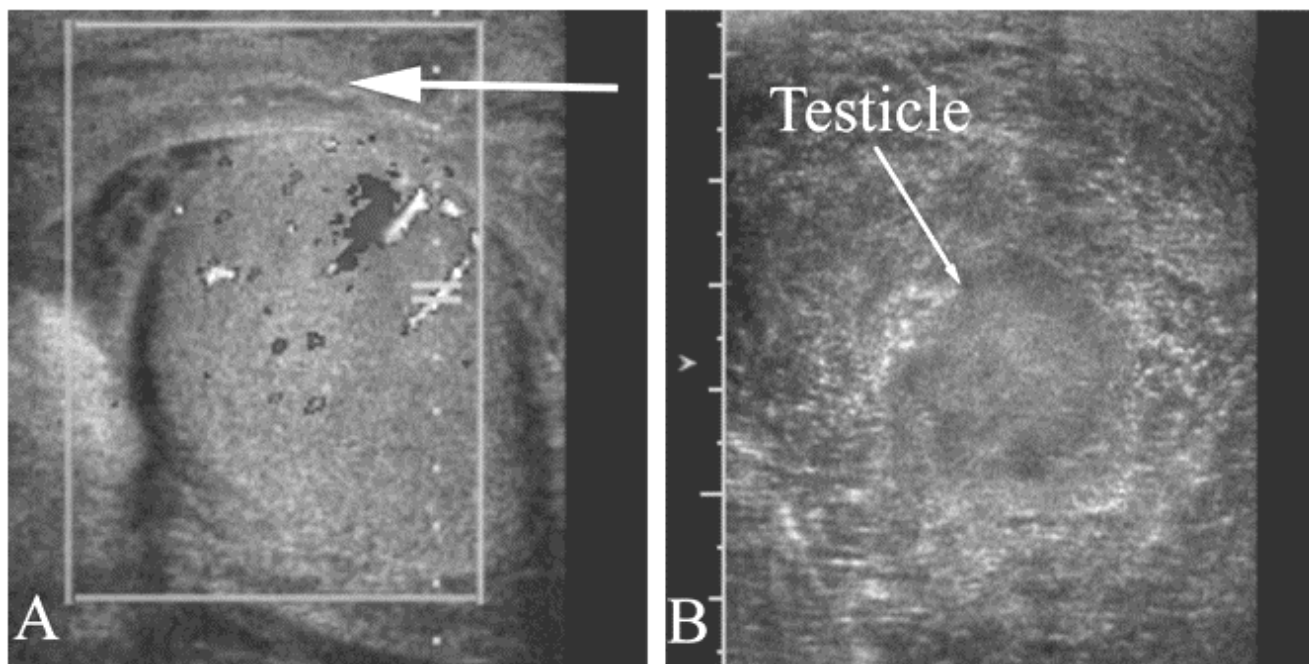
Fournier’s gangrene in a 48 year old with severe pain and swelling of the scrotum for several days. A. Normal testicle with normal flow on color Doppler, but with thick surrounding tissue (arrow). B. The testicle from a different angle, with a larger field of view, demonstrates the testicle swimming in a sea of inflammatory tissue.
